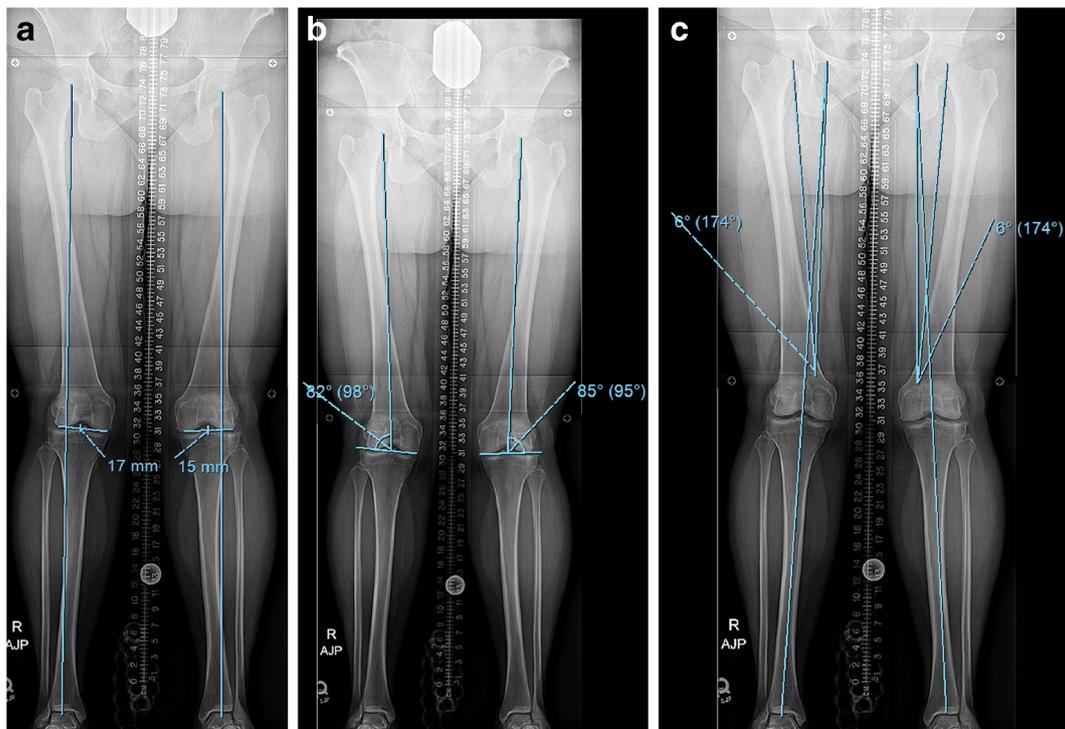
a This 51-in. standing, bipedal radiograph demonstrates bilateral genu valgum with lateral mechanical axis deviations. b The joint orientation angle (LDFA or lateral distal femoral angle) has been measured bilaterally. (Normal mechanical LDFA is 88°; range, 85°–90°). c The preoperative planning for correction of genu valgum has been done, showing a 6° correction will achieve a neutral mechanical axis.
